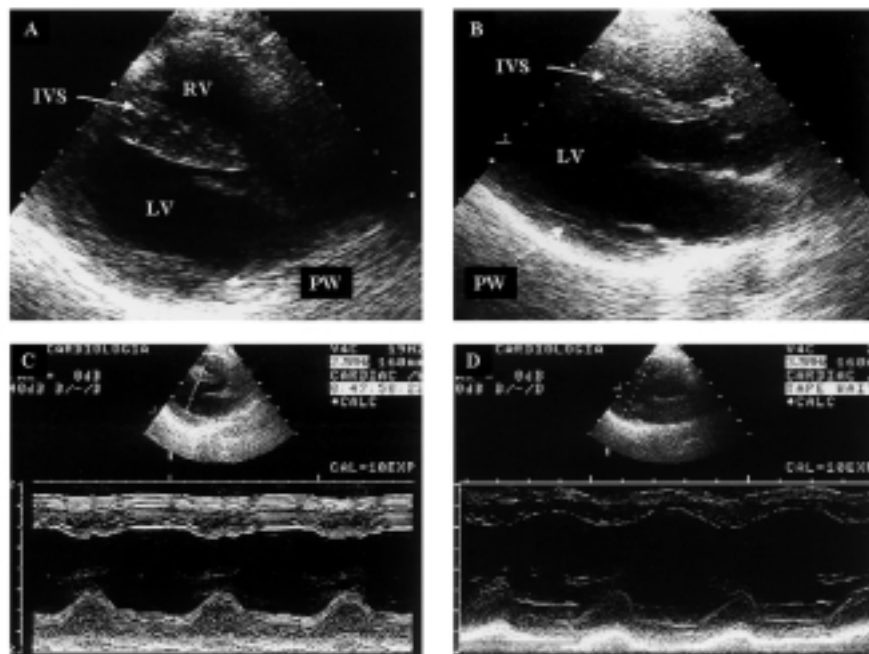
Comparison between echocardiographic examinations at different moments of the clinical course. Two-dimensional and M-mode images on the parasternal long-axis views showed a wall thickening and reduced diameters of the left ventricle (LV) at the time of symptom onset (A and C). After graft treatment, the wall thickness and cavity dimensions returned to normal (B and D). IVS = interventricular septum; PW = left ventricular posterior wall; RV = right ventricle.
